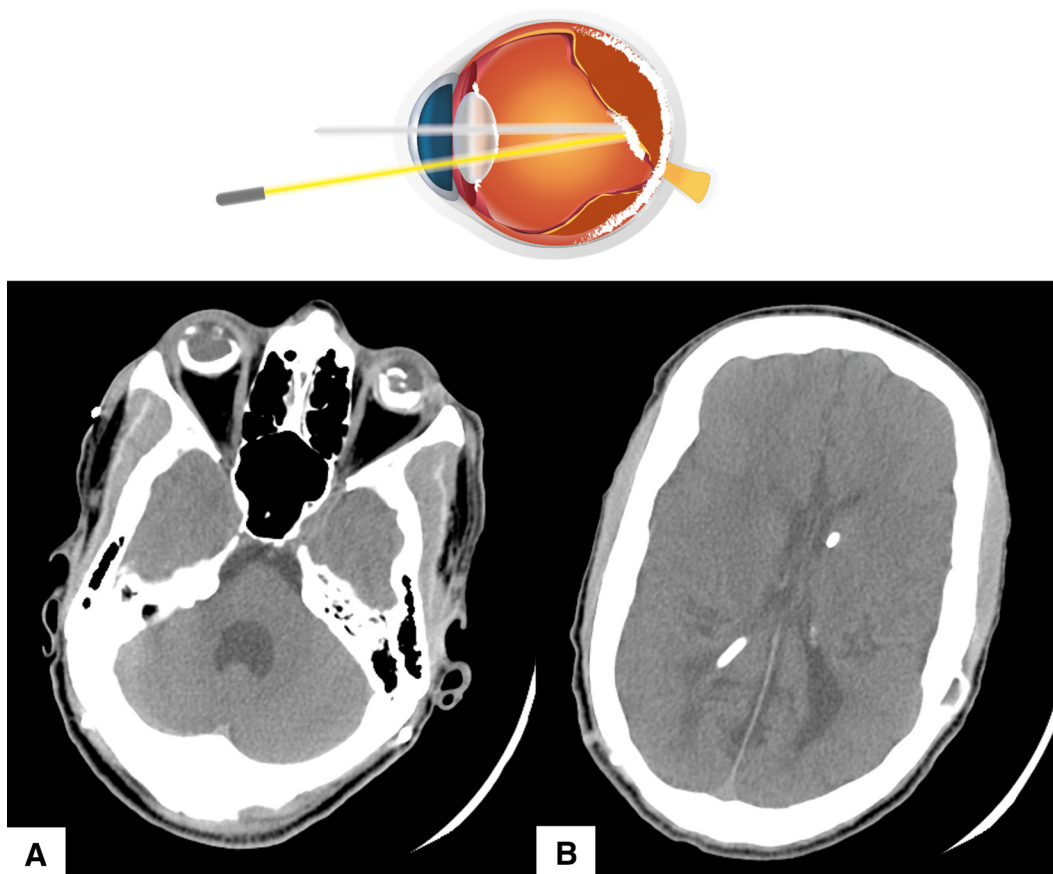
ROP. Axial image from a noncontrast CT of the brain shows the small size of both eyeballs and dense calcifications of retrobulbar tissue and chorioid (A) due to late-stage changes of ROP. Periventricular leukomalacia is also present (B).
